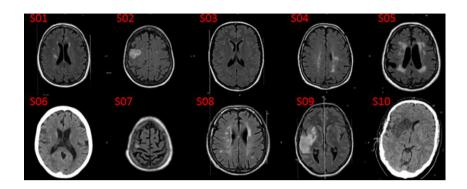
T_1 -weighted MRI (S01-S05 and S07-S09) or CT (S06 and S10) images at the level of maximum infarct volume for each stroke subject. S01, S03, S04, S05 and S08 show subcortical infarcts; other scans show cortical infarcts.
